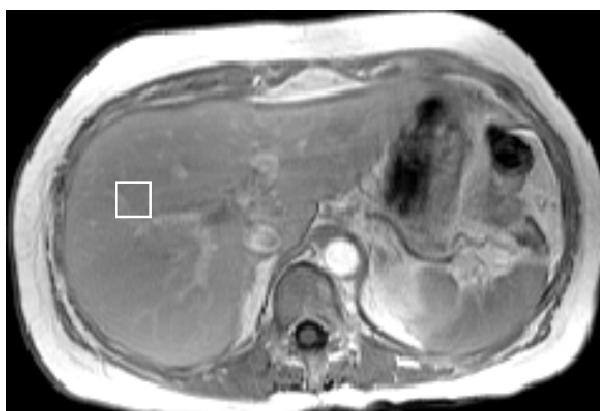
12×12 ROI block drawn on healthy liver in a MR image of the abdomen.
